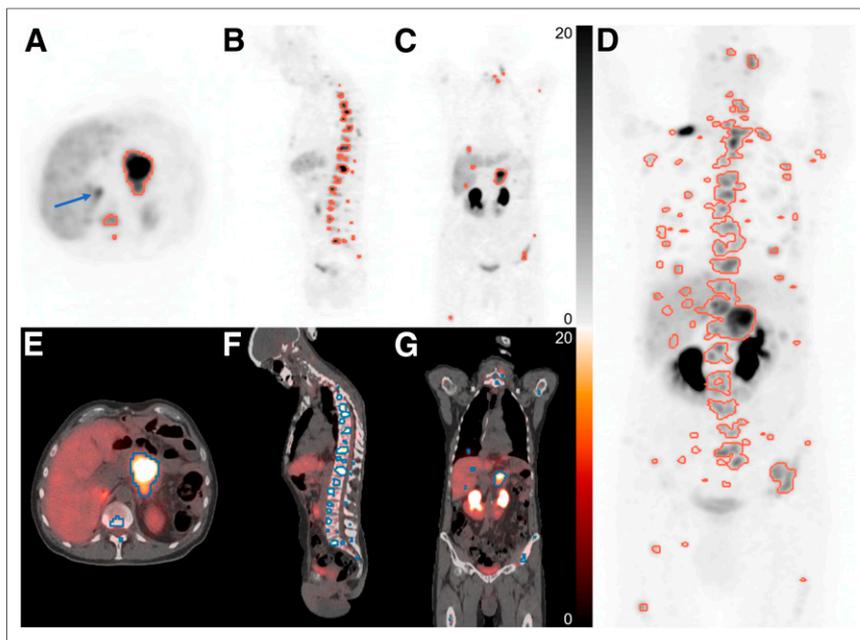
Example of tumor delineation in 65-y-old male patient with pancreatic NET and multiple liver, lymph node, and bone metastases on transversal (A and E), sagittal (B and F), and coronal (C and G) PET/CT and maximum-intensity-projection (D) images. Arrow indicates physiologic uptake in right adrenal gland. Both scale bars apply to PET images in unit SUV.
